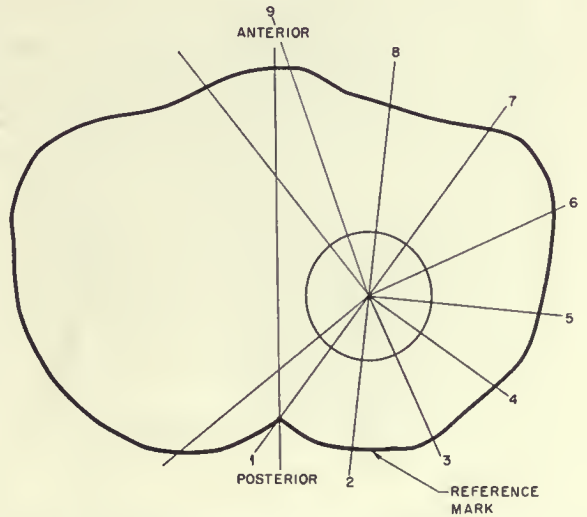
Irradiation technique for carcinoma of the cervix in the form of a presciatic mass, recurrent after previous radium and X-ray therapy.
